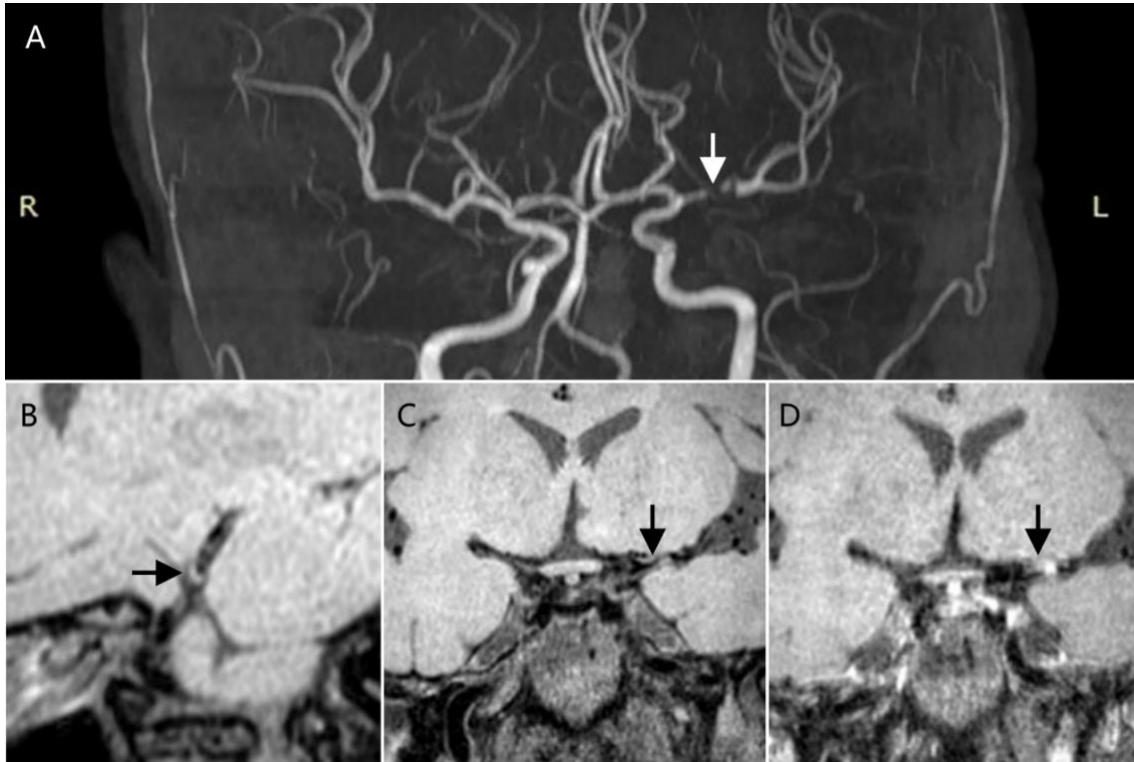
A 59-year-old female patient with acute ischemic stroke caused by a left MCA atherosclerotic stenosis. A, a symptomatic atherosclerotic stenosis of the left MCA-M1 segment on the MRA image (white arrow). B, an eccentric, focal plaque in the left MCA-M1 segment on the T1w image (black arrow). C and D, the plaque in the left MCA-M1 segment before and after administrating contrast on the T1w images, respectively (black arrows). MCA, middle cerebral artery; MRA, magnetic resonance angiography; T1w, T1-weighted.
